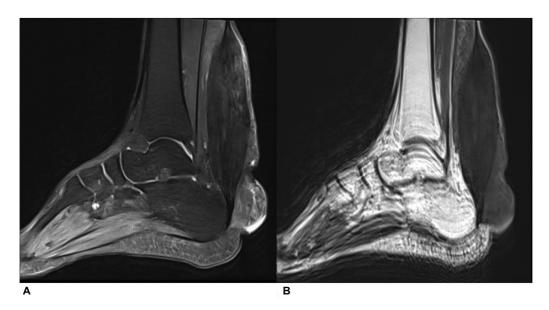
Images in the sagittal plane, proton density-weighted (A) showing thickened Achilles tendon with linear high signal stripes and heterogeneous signal intensity lesion with focal areas of high signal intensity in the subcutaneous plane, posterior to the site of insertion of the Achilles tendon. T1-weighted images (B) showing the thickened and hypointense tendon with hypointense lesion in the subcutaneous plane, posterior to the site of insertion of the Achilles tendon.
